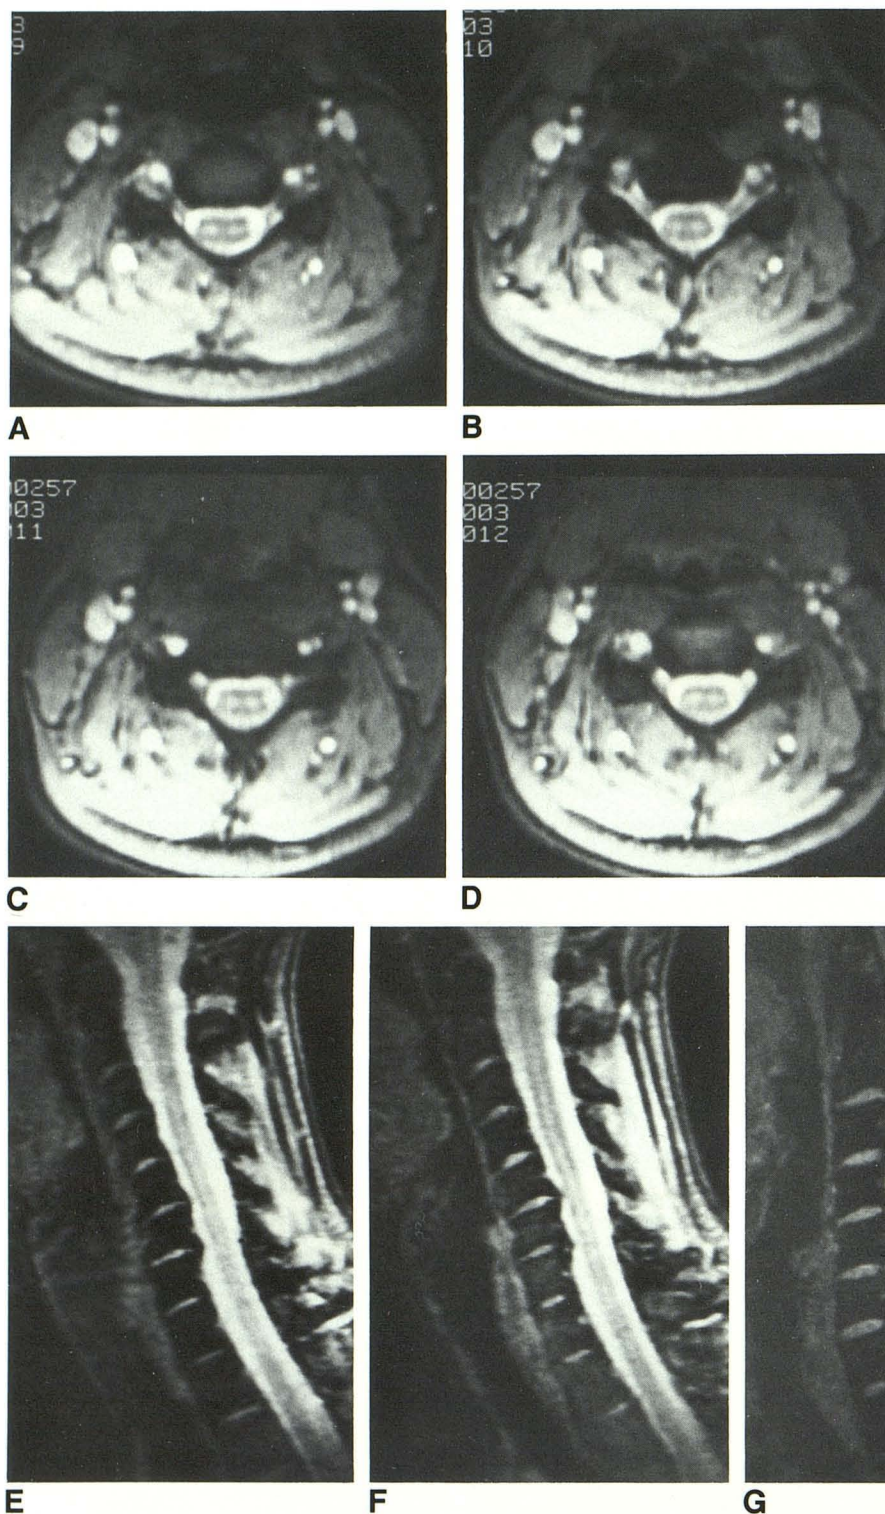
Normal GRASS MR of cervical spine. A–D, Axial MR images (TR = 75 msec, TE = 12.3 msec, flip angle at 10°). Clear delineation of spinal cord, CSF, neural foramina, and nerve roots at C4–C5 and C5–C6 levels. Also note carotid artery bifurcation, vertebral arteries, and jugular vein.
